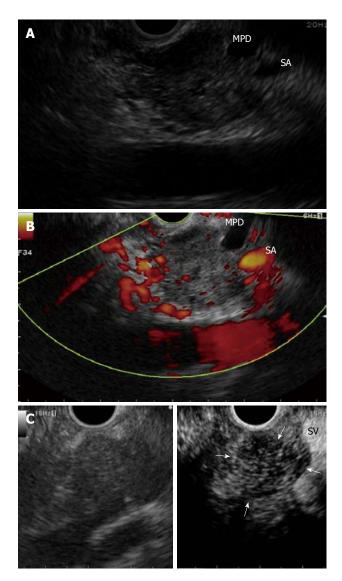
Pancreatic adenocarcinoma. A: EUS shows a heterogeneous hypoechoic mass with irregular margins at the body of the pancreas and tail side main pancreatic duct enlarged due to the infiltrating mass; B: Contrast-enhanced power Doppler EUS shows a hypovascular nodule compared with the surrounding pancreatic tissue; C: Contrast-enhanced harmonic EUS showing a clear margin and hypovascular nodule compared with surrounding pancreatic tissue (arrows) without blooming artifact such as that found with Doppler imaging. Left: B-mode imaging; Right: Contrast imaging. MPD: Main pancreatic duct; SA: Splenic artery.
